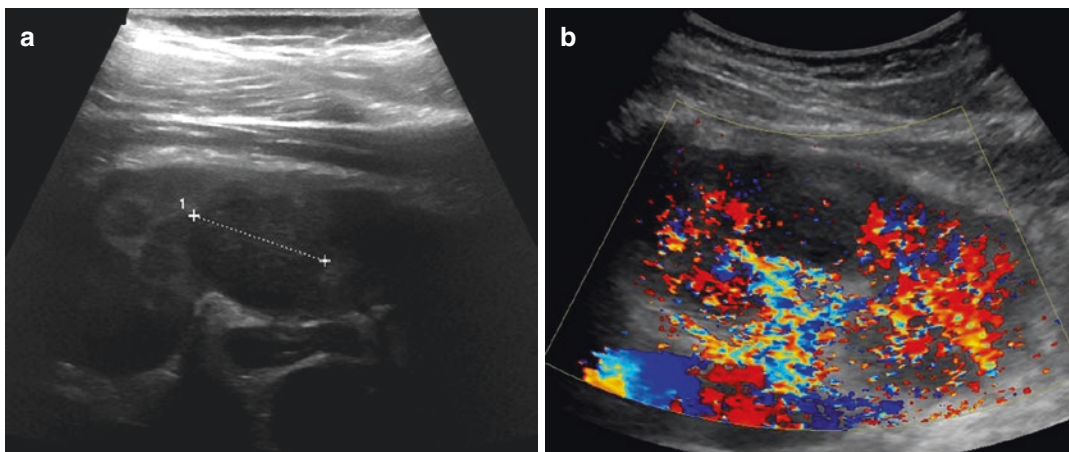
Renal abscess. Longitudinal sonogram (a) shows a thickened pelvic wall with peripelvic fat hyper-echogenicity along with a hypoechogenic round area
